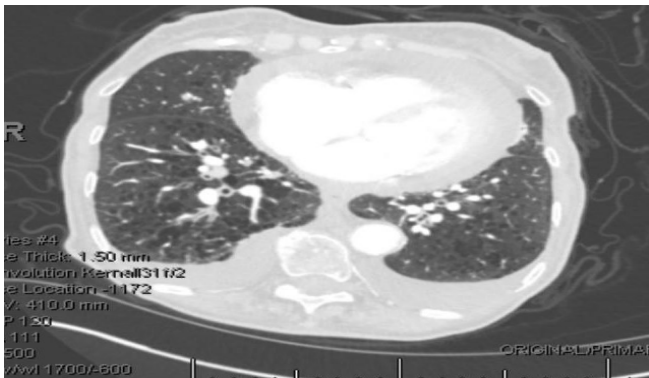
CT(computed tomography) of the chest showing moderate pericardial effusion. Image 121/160— 1.5 cm nodule
